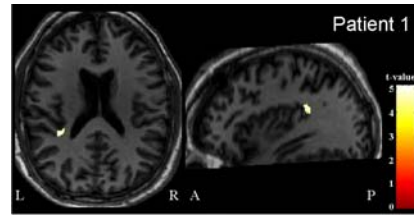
Area showing significant decrease of FA in the white matter of patient 1 in comparison to the collection of normals ($p_u < 0.001$) superimposed on the normalized T1-weighted anatomical image of patient 1 (Talairach-coordinates: -36, -41, 19). L = left; R = right; A = anterior; P = posterior.
